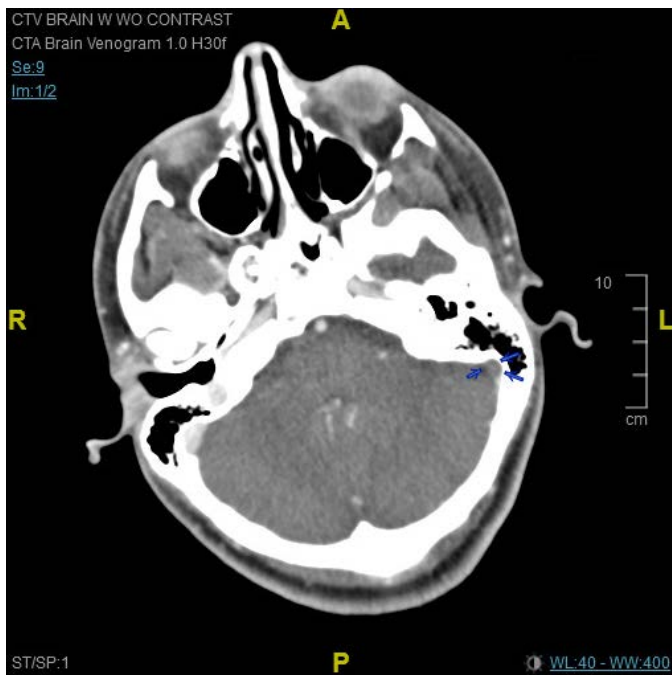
CT brain venogram with contrast (axial). Thrombosis of the left sigmoid sinus and left internal jugular vein (arrows). The thrombus ends at the left transverse sinus, which remains patent.
